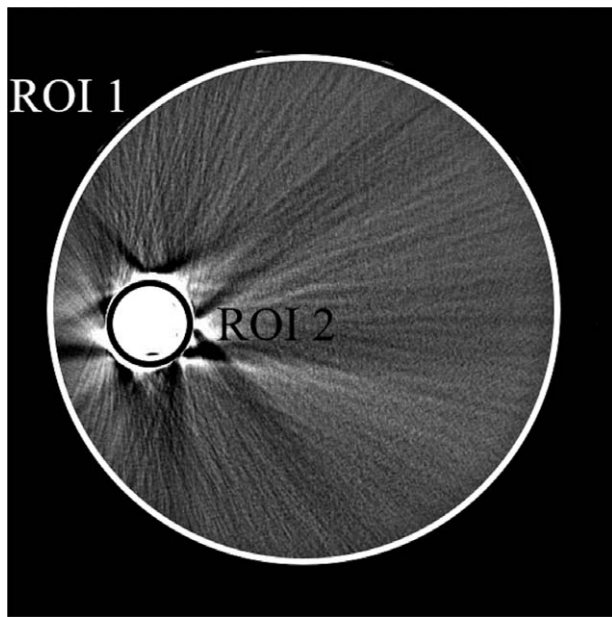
For the assessment of dark bands, pixels with computed tomography values of less than the threshold within ROI 1, excluding ROI 2, were detected. ROI = region of interest.
